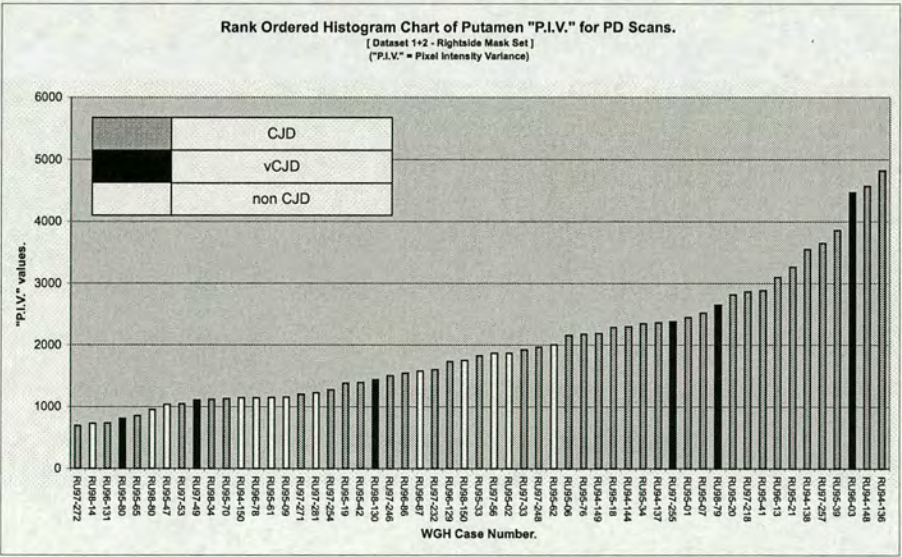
Bilateral Symmetry Tests: Rank ordered histogram of the Putamen "P.I.V." for the PD weighted MRI scan-data from the combined data-sets 1 & 2 generated using the rightside mask image-set.
